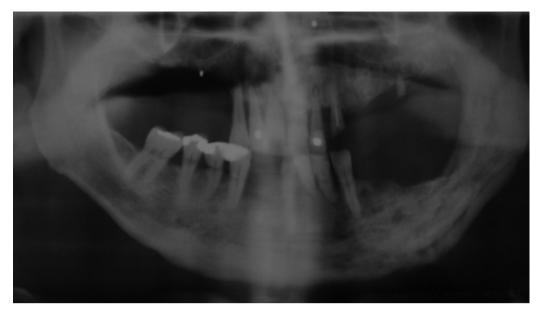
Panoramic x-ray showing bisphosphonate-induced osteonecrosis in the left jaw
